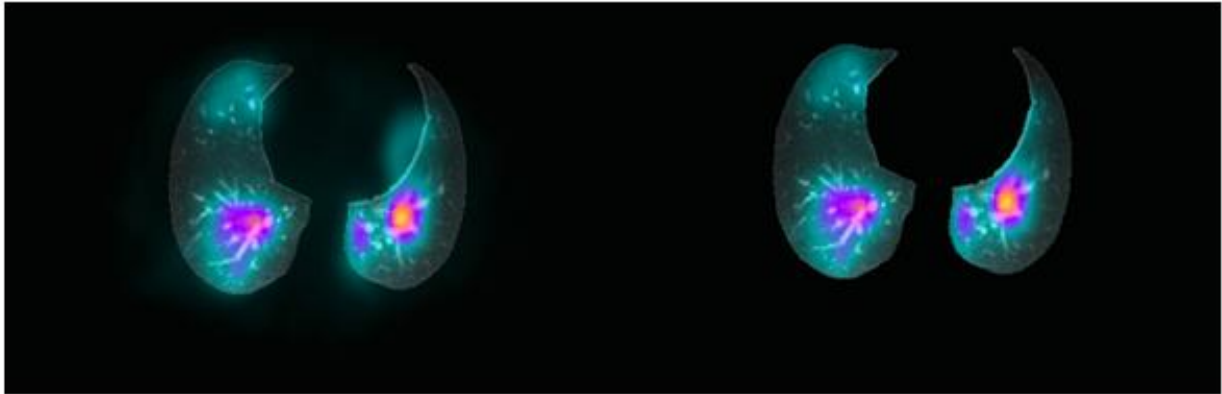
CT masks are overlaid into VSPECT.
